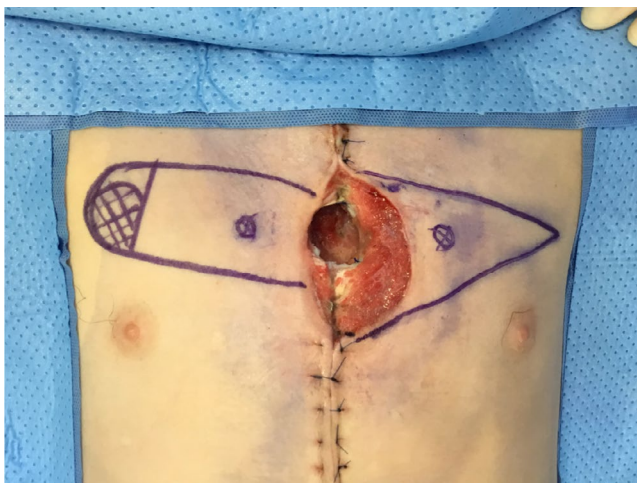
Image showing sternal skin defect of 7 × 4 cm and bone defect of 3 × 3 cm with exposed pericardium. The perforators identified on Doppler are marked. The 12 × 4 cm propeller flap was planned on the right side, based on the position of the perforator and the defect. The area to be de-epithelialized is marked on the distal aspect of the flap. The V-Y flap was planned on the left
